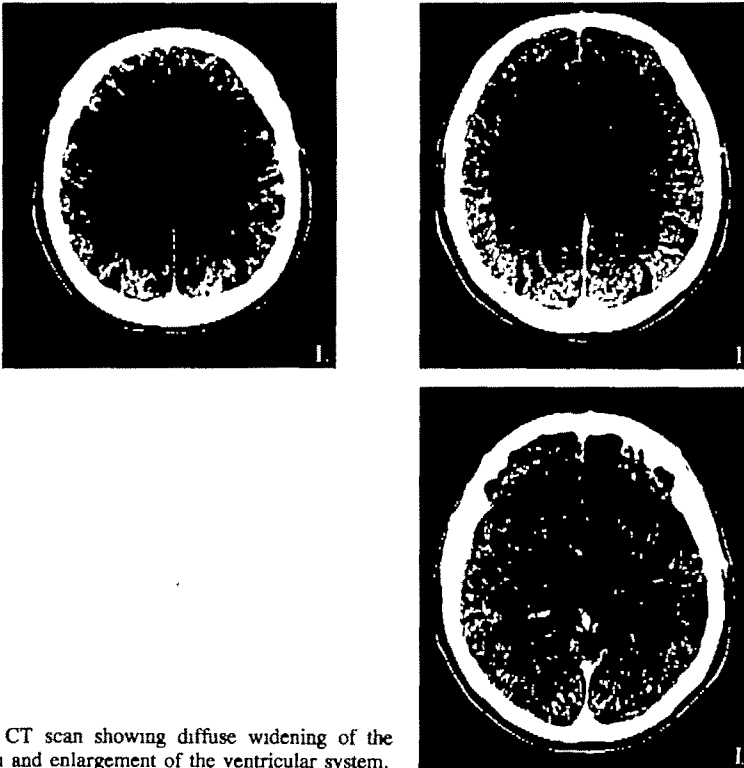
A CT scan showing diffuse widening of the cerebral sulci and enlargement of the ventricular system.
